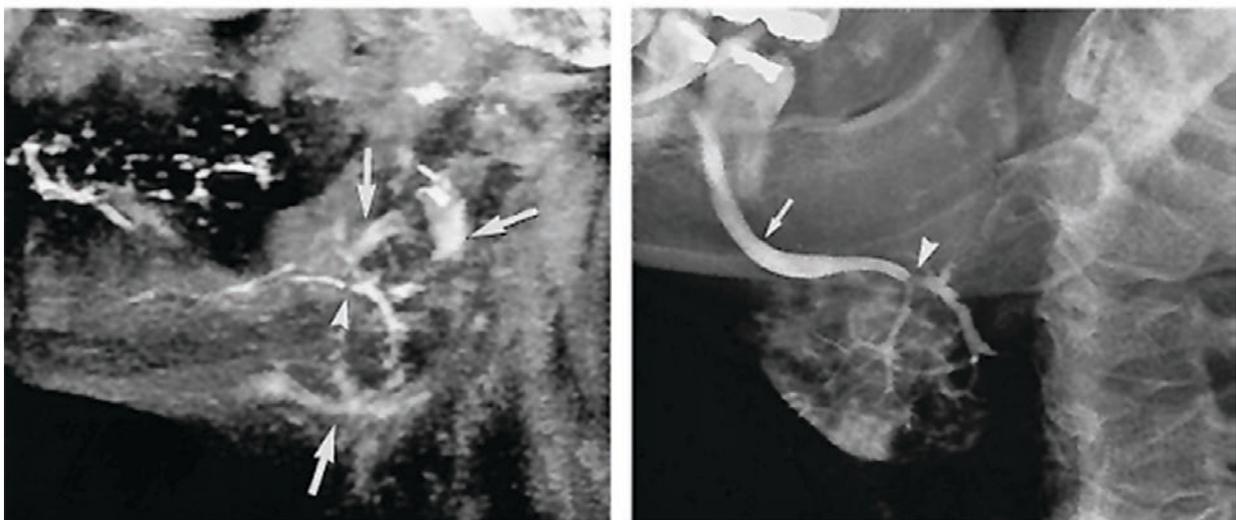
MIP reconstruction on MRI versus conventional sialography
